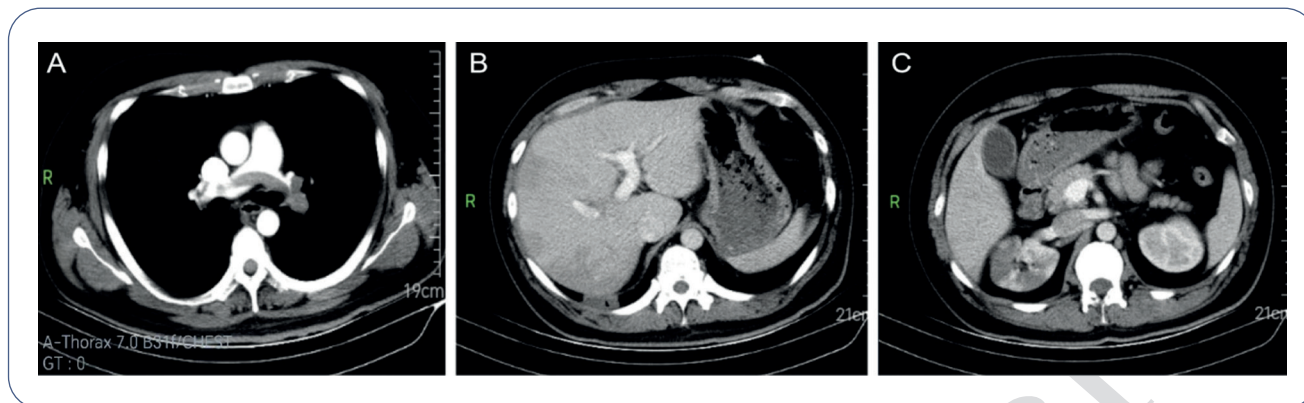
Computed tomography scan showing pulmonary embolism (A), right hepatic infarction (B), and right renal infarction (C).
